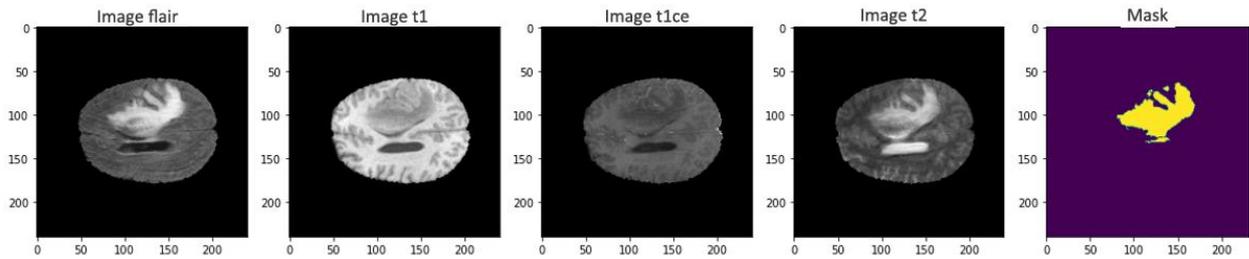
Preprocessing steps of MRI image.
